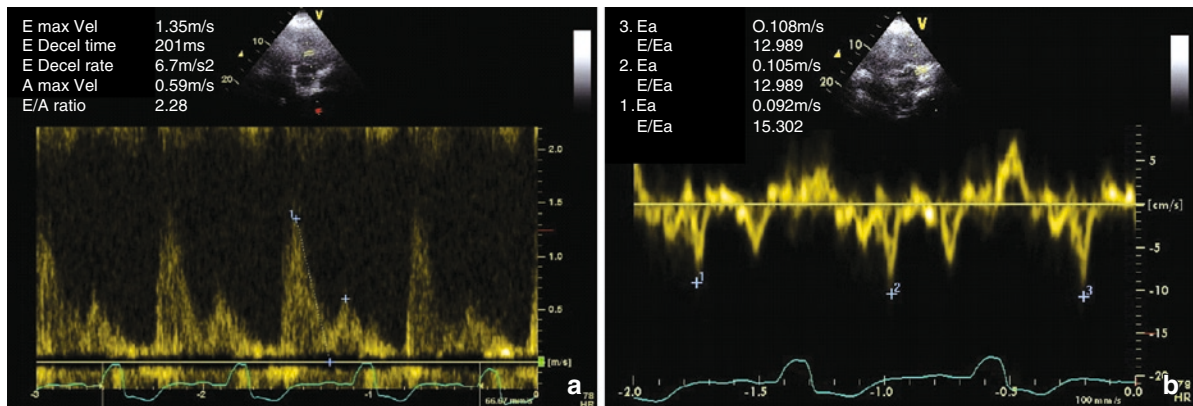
Mitral inflow pattern recorded using pulsed Doppler (a) and early diastolic velocity of the lateral mitral annulus recorded using tissue Doppler imaging (b) in a patient with elevated left ventricular end-diastolic pressure
